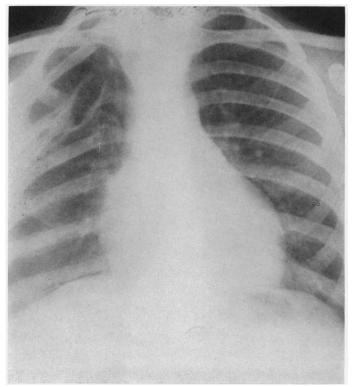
X-ray of chest on April 29, 1933, without evidence of recurrence.
